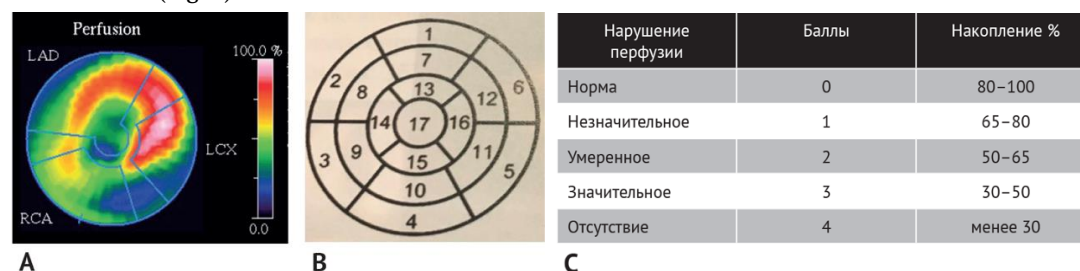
Volumetric image of myocardial perfusion during single photon emission computed tomography: A — an example of inclusion of ^{99m}Tc -technetrite according to the main systems of the coronary blood supply, "bull's eye"; B — 17-segment bull's-eye model; C — scores and their correspondence to the accumulation of the radiopharmaceutical in %.
